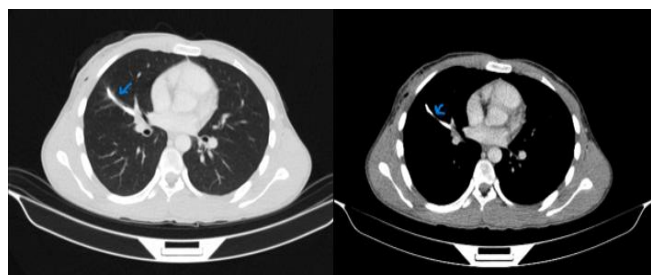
Thoracic CT scan without contrast showed a 7 cm long foreign body in the pulmonary artery, which was thought to be a catheter fragment
